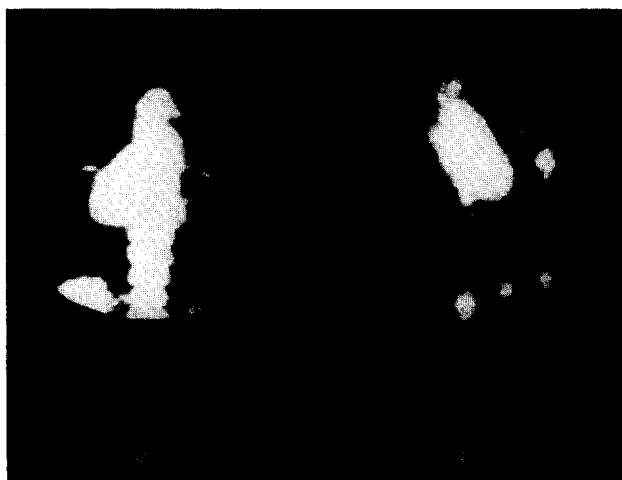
Octreotide scintigraphy in a patient with disseminated SCLC (case 12), 24 h after injection of ^{111}In -(DTPA-D-Phe1)octreotide. Scintigraphy demonstrates primary tumour (arrow), multiple bone lesions and medullar involvement. (a) Posterior view of thorax; (b) anterior view of thorax, arrow: primary tumour.
